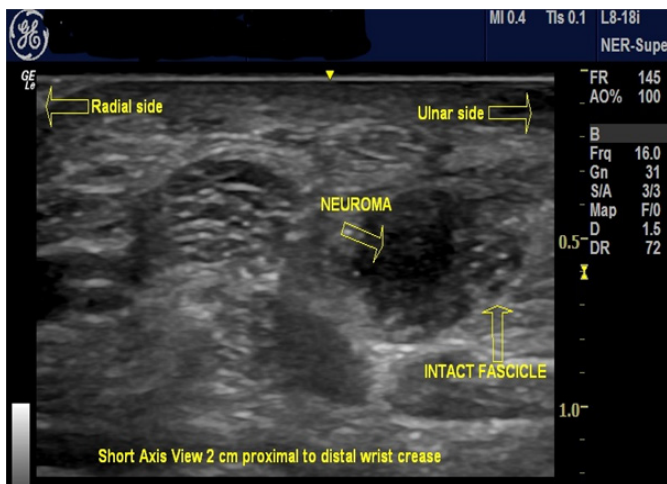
Ultrasonic image: Short axis view of the left median nerve at the site of injury. Note the hypoechoic enlargement with loss of fascicular pattern and an intact fascicle on the ulnar side of the nerve.
